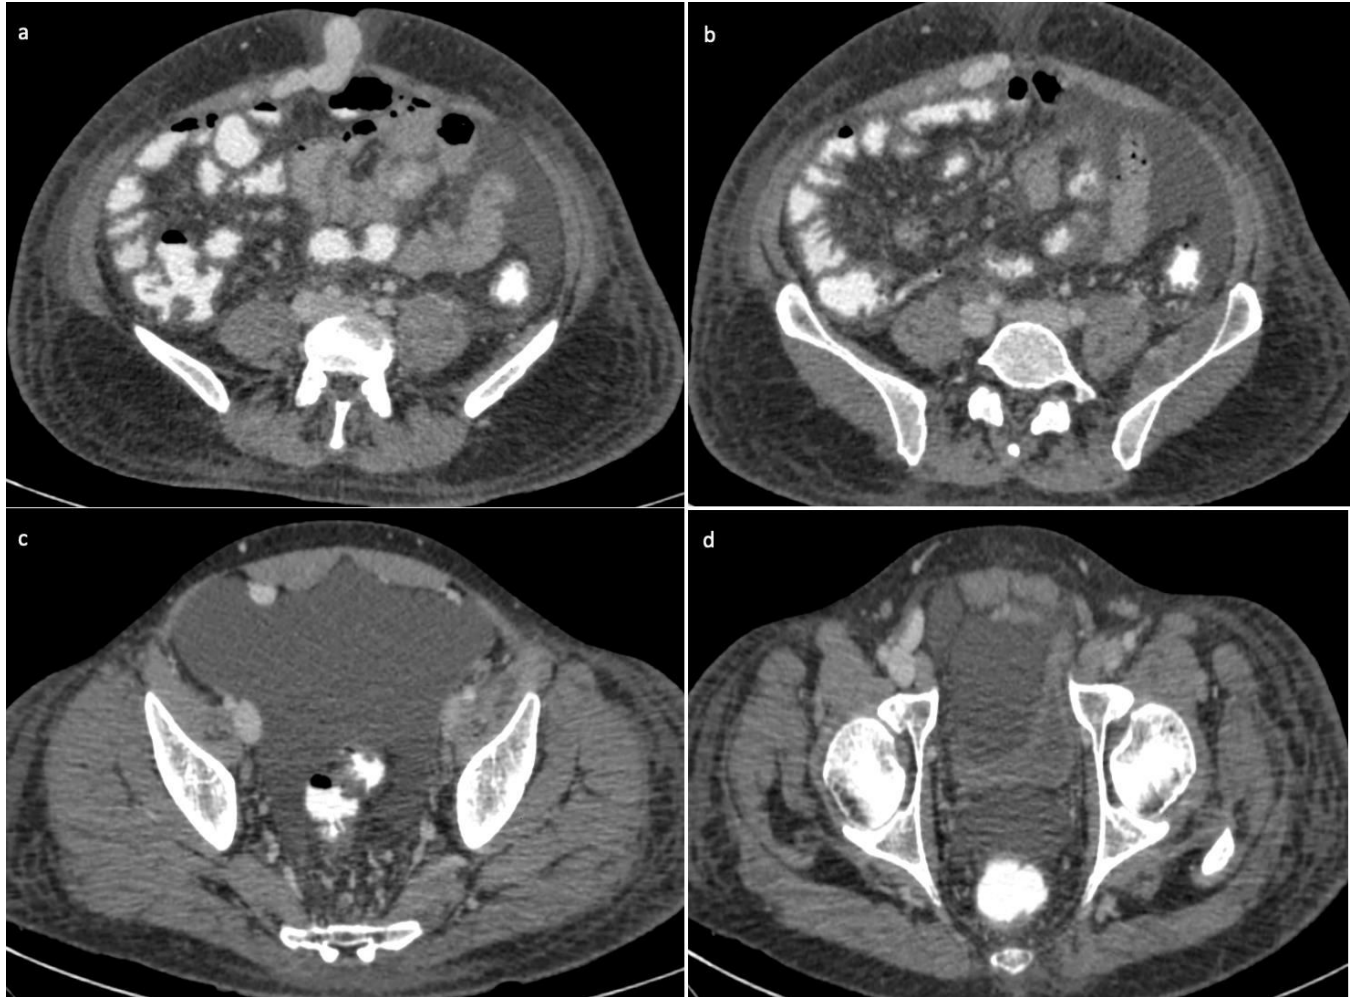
& Figure 6b: Axial CT abdomen post contrast images reveal herniated left paraumbilical vein through anterior abdominal wall defect in umbilical region.
